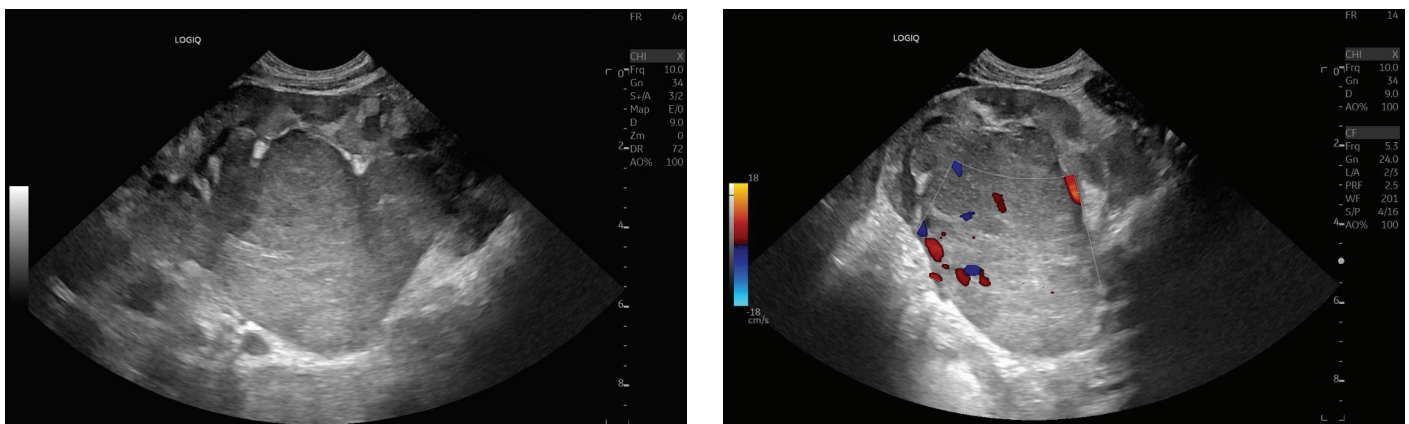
Gray-scale and color-doppler ultrasound images.
